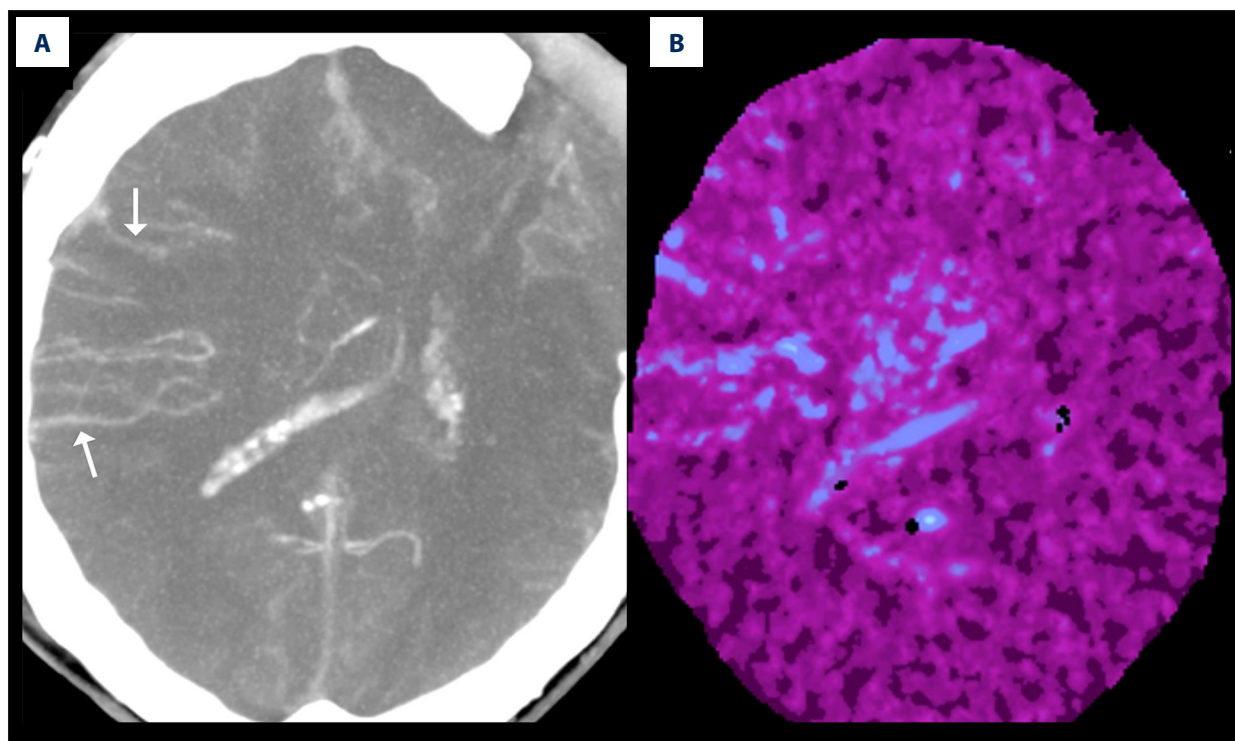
Results of CTA (A) and CTP (B) in the patient clinically diagnosed with brain death. CTA shows filling of cortical branches of the right MCA (arrows) and was classified as negative (i.e., inconsistent with the diagnosis of BD). CTP reveals perfusion values below the thresholds for nonviable tissue and was interpreted as positive (i.e., consistent with the diagnosis of BD).
